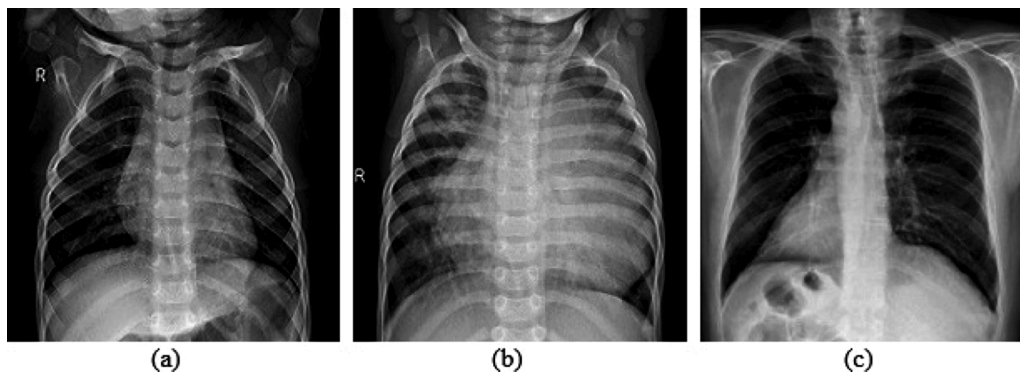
X-ray Images: (a) Normal (b) non-COVID Pneumonia (c) COVID-19.
